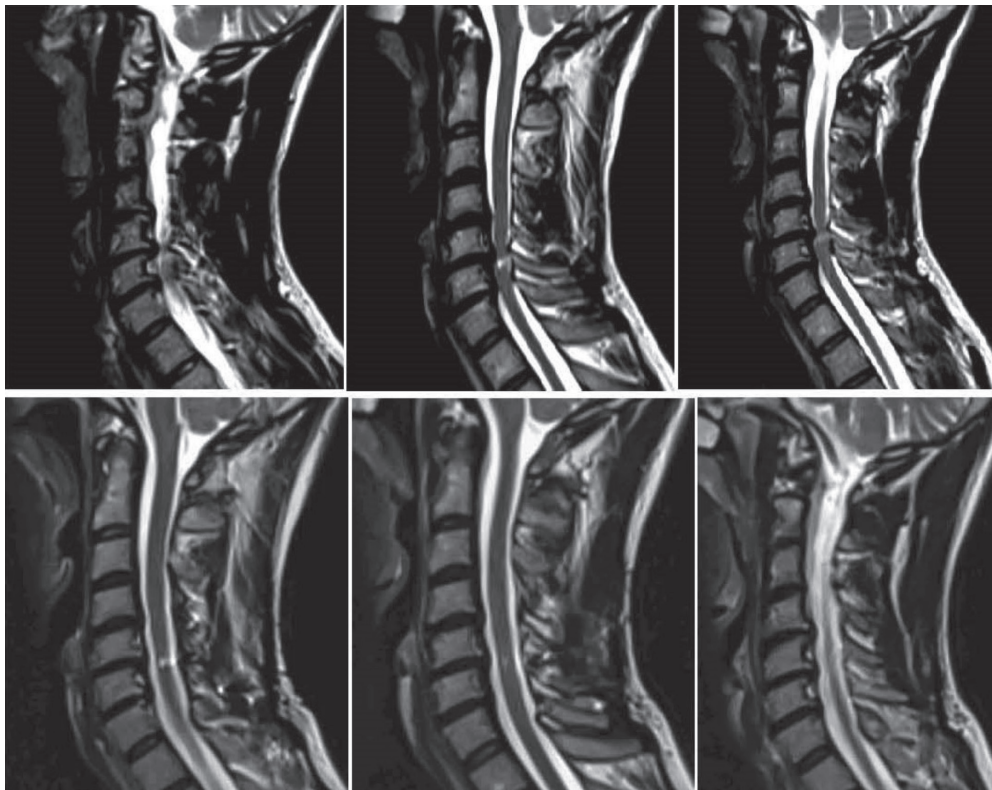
MR images before and after surgery (en-bloc laminoplasty technique) for cervical spondylotic myelopathy
